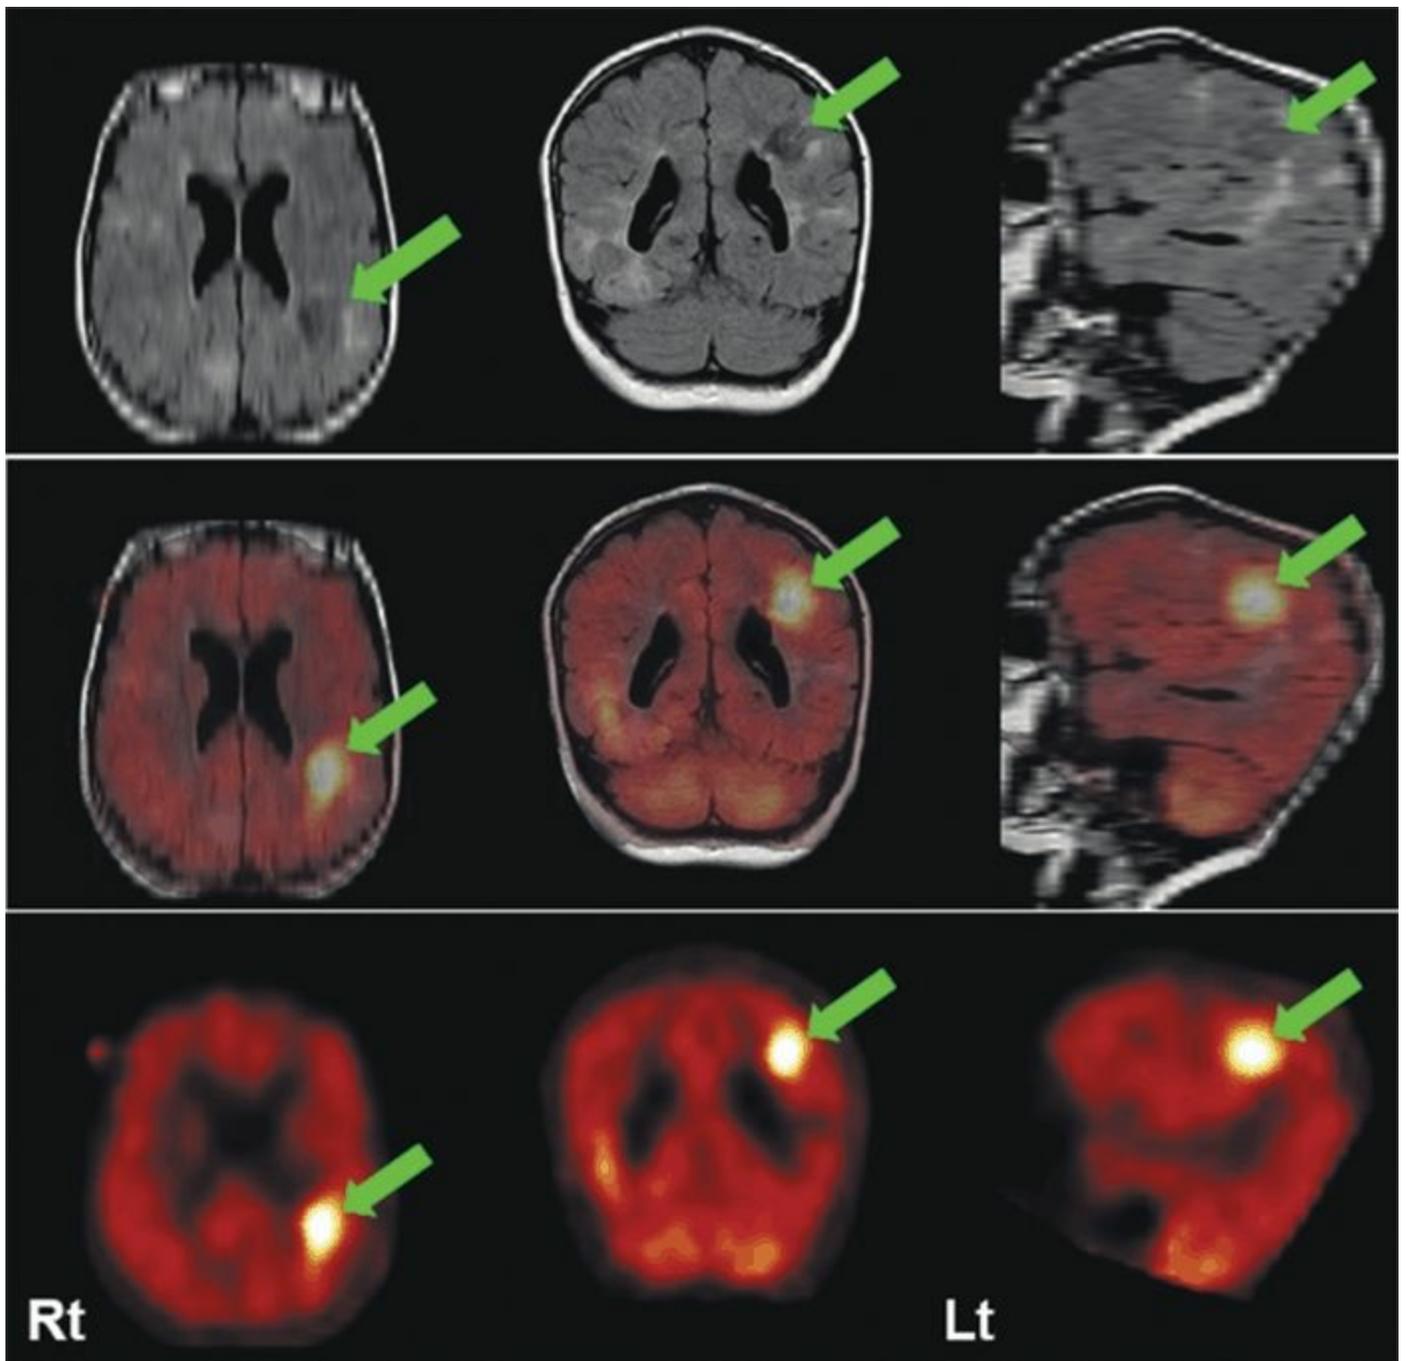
MRI (FLAIR) (upper row) and [^{11}C] AMT-PET (bottom row) and coregistered images (middle row) in a 2-year-old child with tuberous sclerosis. [^{11}C] AMT-PET shows markedly increased ligand uptake in epileptogenic parietal tuber (arrow) that is hypometabolic with [^{18}F]FDG-PET (not shown). (Courtesy of Dr. Harry Chugani, Detroit Children's Hospital.)
